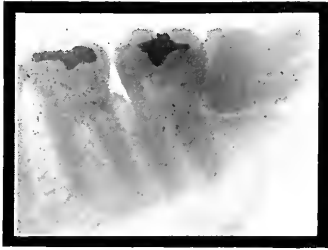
Radiographs of completely impacted inferior third molars. The teeth are in horizontal position, with all or nearly all of the occlusal surface of the crown of the third molar impinging on the second molar.
